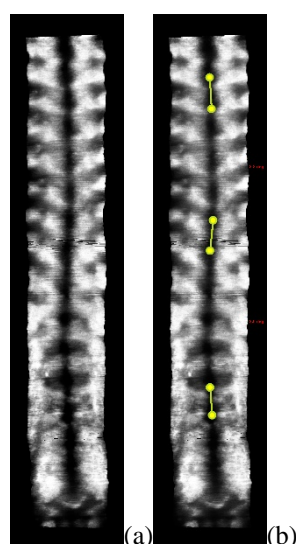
The ultrasound image generated by VPI method. (a) Original VPI image; (b) image with measurement result.
